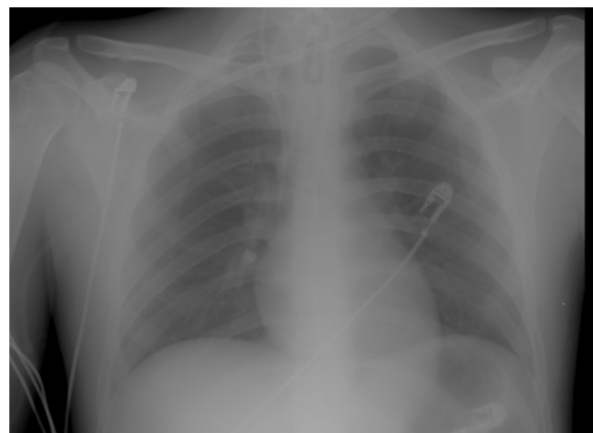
A tooth on X-ray
